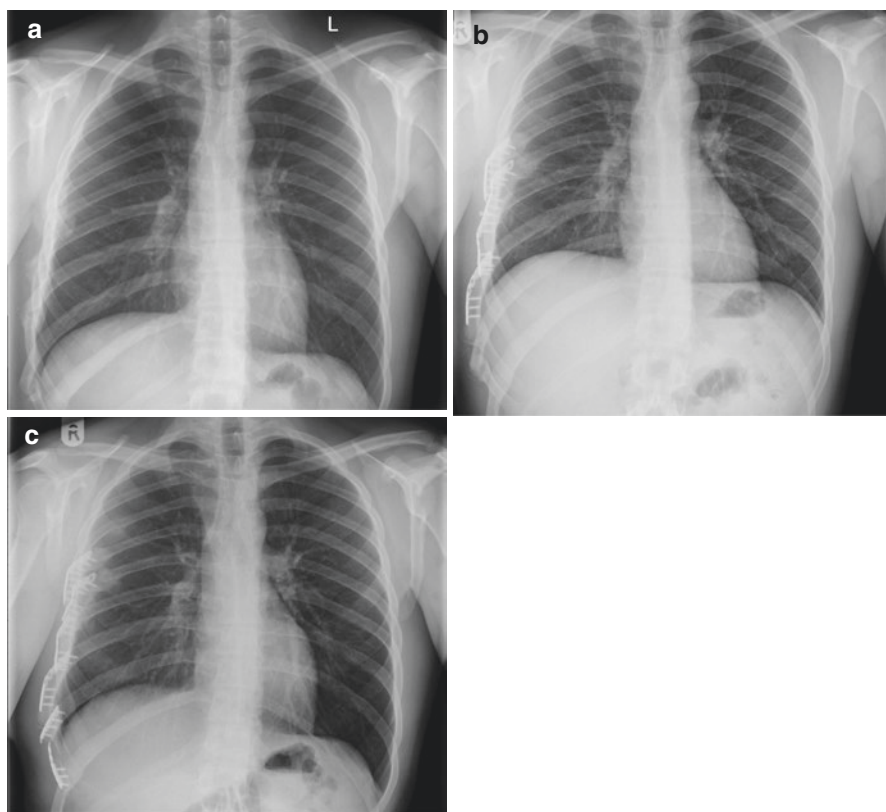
A 21-year-old male tennis professional with spontaneous right sixth–eleventh NURFs. (a) Chest radiograph demonstrating hypertrophic NURFs. (b) Chest radiograph 3 months after SSNURFs of the right. The tenth rib fracture felt united and was not stabilised. However, pain localised to this persisted, and he underwent further surgery. (c) Plating of the tenth NURF was performed after excision of the non-union, leaving a 1 cm gap which was not bone grafted. The titanium plate fractured 3 weeks postoperatively
